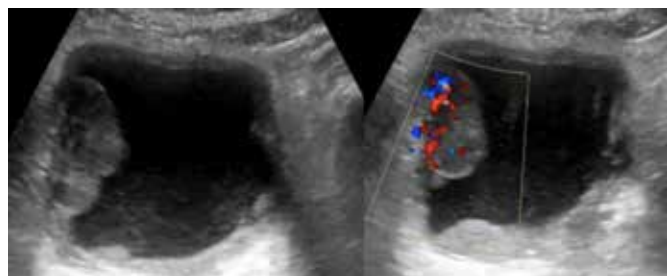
(a) Large well-defined echogenic mass (4.0×2.0×3.7cm) on the right lateral wall of the bladder. (b) Color Doppler ultrasonography detected the presence of vascularization in this mass. Urothelial carcinoma was confirmed.³
